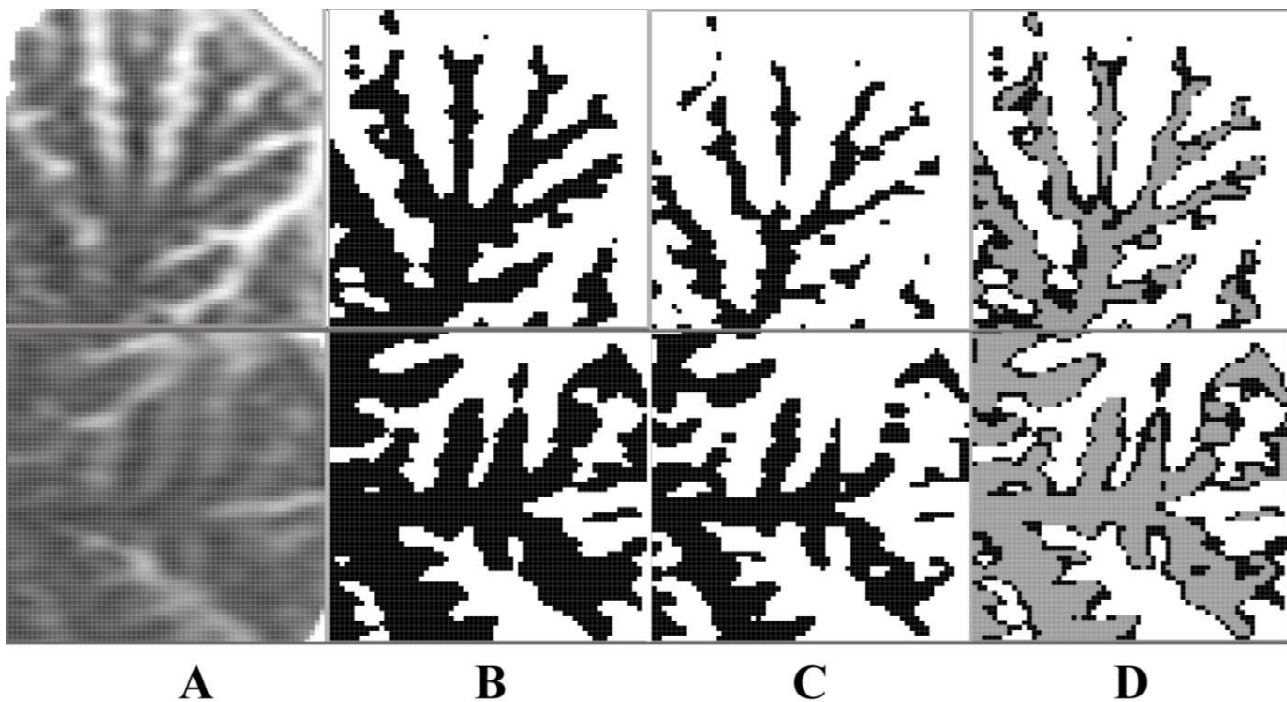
Segmentation of digital image of magnetic resonance imaging of the human cerebellum. The upper row of images - upper lobe of the cerebellum, the lower row - lower lobe. A - the original image; B - segmentation with a threshold value of brightness 100, C - segmentation with a threshold value of brightness 90, D - the difference between the thresholds 100 and 90, which corresponds to the contour of the cerebellum, is shown in black color.
